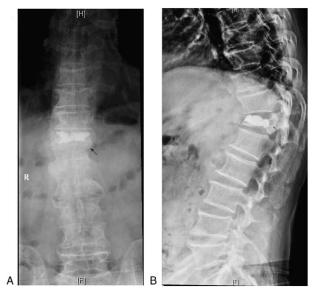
Anteroposterior x-ray film (a) and lateral x-ray film (b) were taken at 1 day post-operation. For the patient in Fig. 1, this shows that the anterior vertebral compression rate was approximately 50%.
